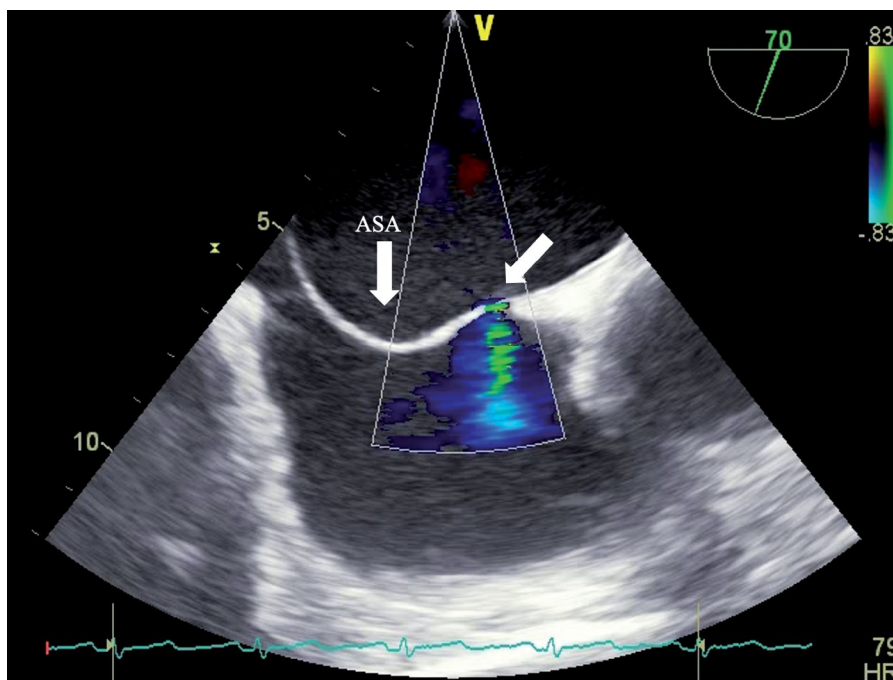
Transesophageal echocardiogram showing giant atrial septal aneurysm (ASA) and atrial septal defect (ASD).
